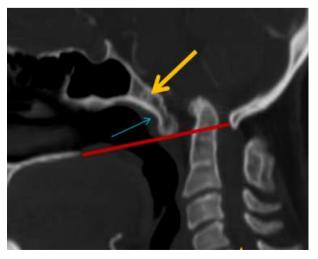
Basiocciput hypoplasia. CT sagittal section showing short clivus (yellow arrow), atlantooccipital assimilation (blue arrow) and violation of Chamberlain's line (red line).
